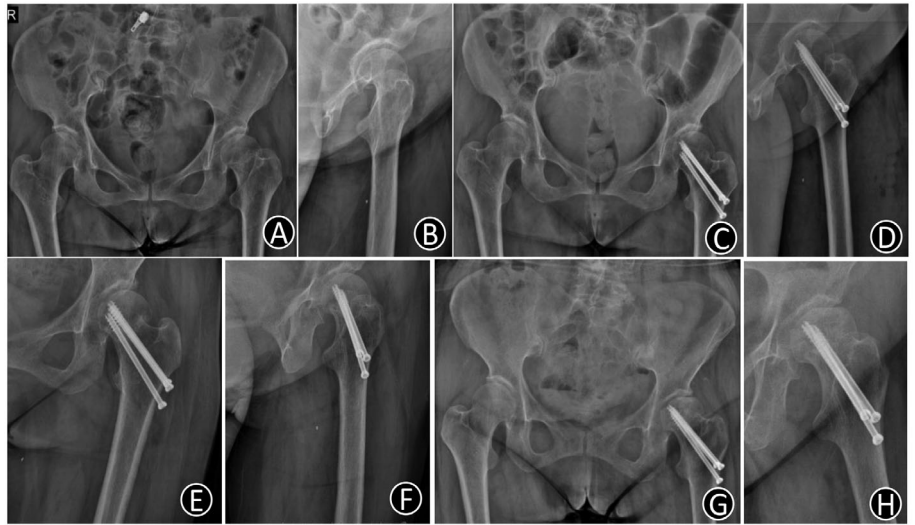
A 66-year-old female patient had nonunion of femoral neck after three-screw fixation in inverted triangle configuration. (A, B) Preoperative anteroposterior and lateral radiographs of left hip joint. (C, D) Postoperative anteroposterior and lateral views. (E, F) Anteroposterior and lateral radiographs six months postoperatively. (G, H) Anteroposterior and lateral projections at 12 months after surgery showed nonunion of femoral neck fracture. (I, J) Anteroposterior and lateral projections at 24 months after operation showed osteonecrosis of the femoral head and underwent hip arthroplasty (K).
